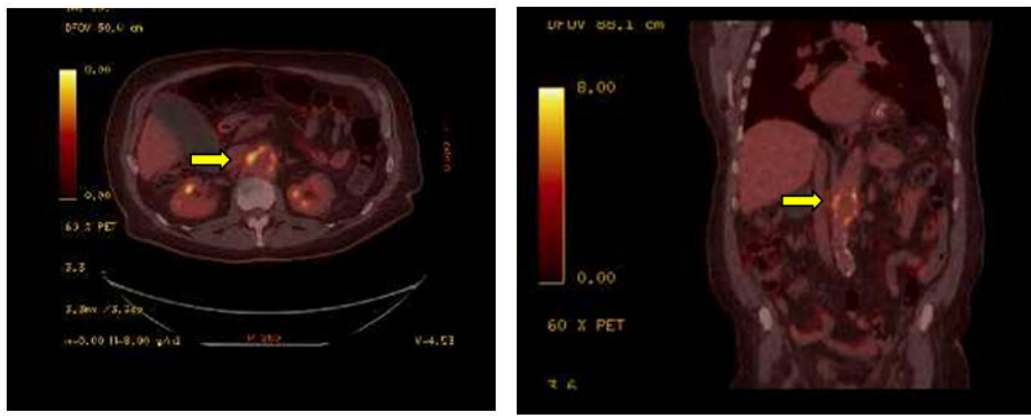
FDG PET scan axial view showing intense accumulation of ^{18}F – FDG around the abdominal aorta (solid arrow). Fig. 2b. FDG PET coronal view showing increased uptake around the SMA origin (solid arrow)
